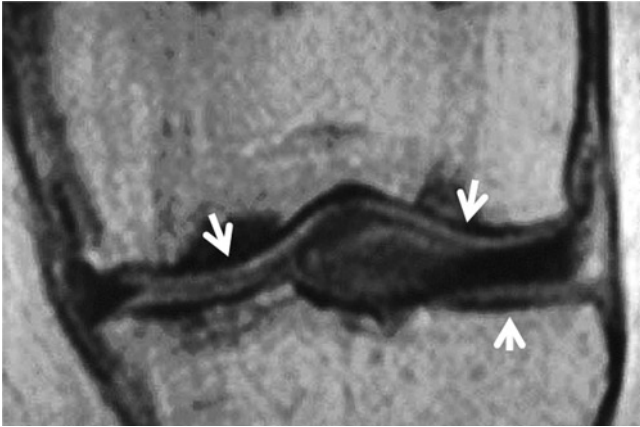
Coronal T1-weighted SE sequence (520/24 ms) of the right knee obtained at 0.2 T with a dedicated extremity scanner in a patient with subchondral bone infarcts. Limitations of image SNR and spatial resolution are clearly demonstrated, which also limits visualization of cartilage abnormalities (arrows)
